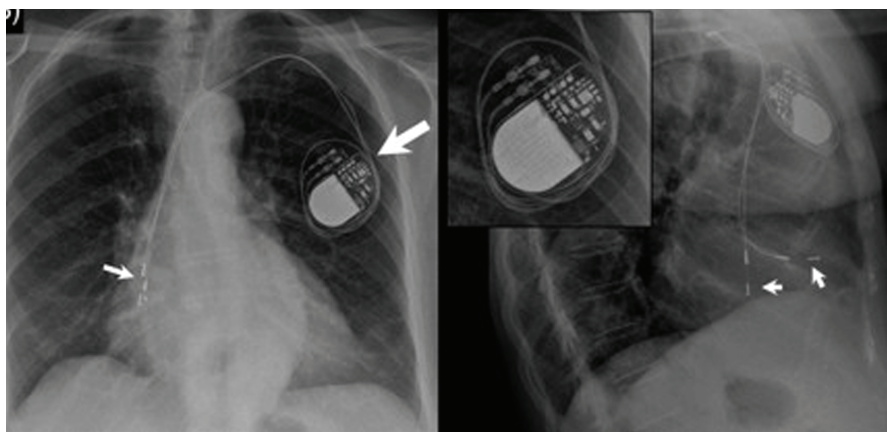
Pacemaker Twiddler syndrome. Postero-anterior and lateral chest X-ray showing displacement of both leads, especially the ventricle one, retracted and floating in the right atrium (arrows).
